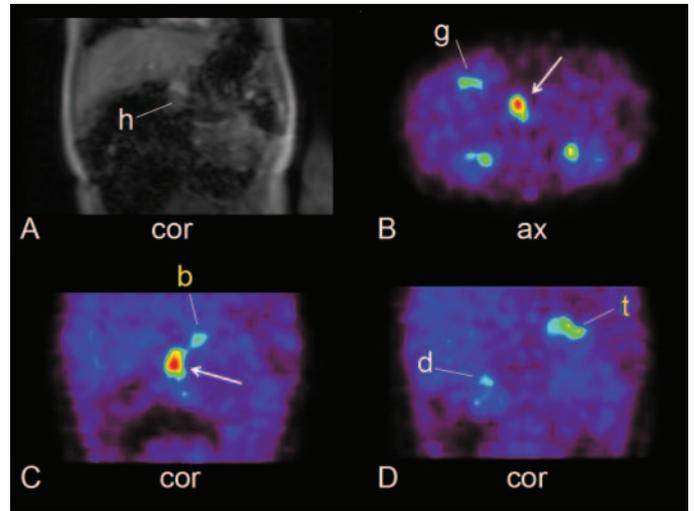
[¹⁸F]-DOPA PET and reference MRI in a 7-month-old infant with a focal form of hyperinsulinism of infancy (patient 3). Coronal MRI (A) of the upper abdomen shows pancreatic head (h) and on PET axial (B) and coronal (C) views a metabolically active focus with a maximum SUV of 6.8 is indicated with white arrow. The maximum SUV of the body of pancreas (b) is 3.1 and that of the tail (t) in another coronal view on PET (D) is 3.1, respectively. Of the normal tissues with increased uptake of [¹⁸F]-DOPA, both gallbladder (g) and duodenum (d) can be seen.
